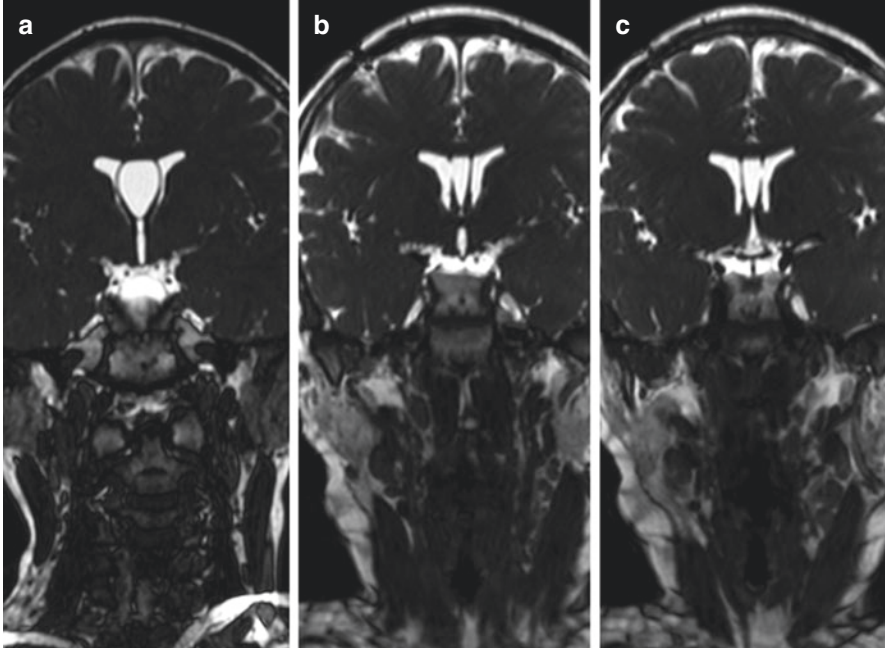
(a) Coronal CISS MR image showing the septum pellucidum cyst with narrowing of both foramina of Monro. (b) Coronal CISS MR image 2 years after surgery showing the fenestration of the right leaflet. (c) Coronal CISS MR image 2 years after surgery showing the fenestration of the left leaflet
